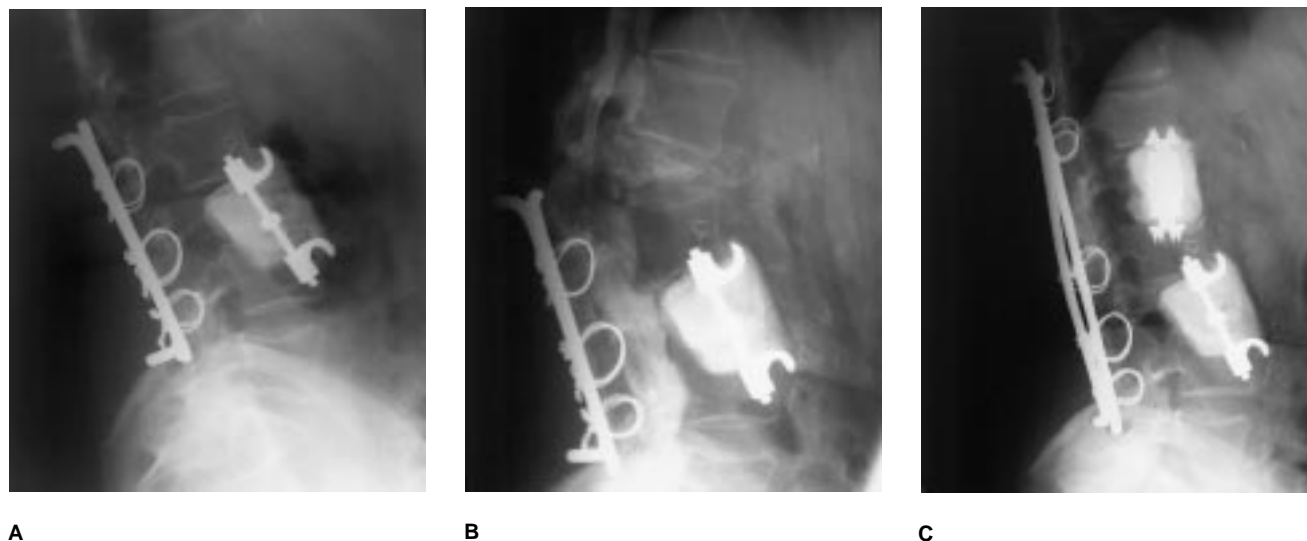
Radiographs of a 65-year-old woman with multiple myeloma, progressive tumor infiltration, and collapse of the L-3 vertebral body. A, The patient presented with a rapidly progressive cauda equina syndrome (Frankel grade C) despite 4,500 cGy of local irradiation. After anterior L-3 vertebrectomy and replacement by methylmethacrylate incorporating a Knodt rod, a posterior four-level stabilization was accomplished with Luque rods and sublaminar wire fixation. The patient enjoyed a complete neurologic recovery. B, Six years later, a new compression fracture appeared at L-1, again associated with a progressive cauda equina syndrome. C, The L-1 vertebral body was replaced using methylmethacrylate incorporating a Rezinian vertebral distractor. The original Luque rods were replaced with longer rods and sublaminar wiring spanning seven levels. Pathologic examination of the resected L-1 vertebral body revealed that it had collapsed because of radiation osteitis, not myeloma.
